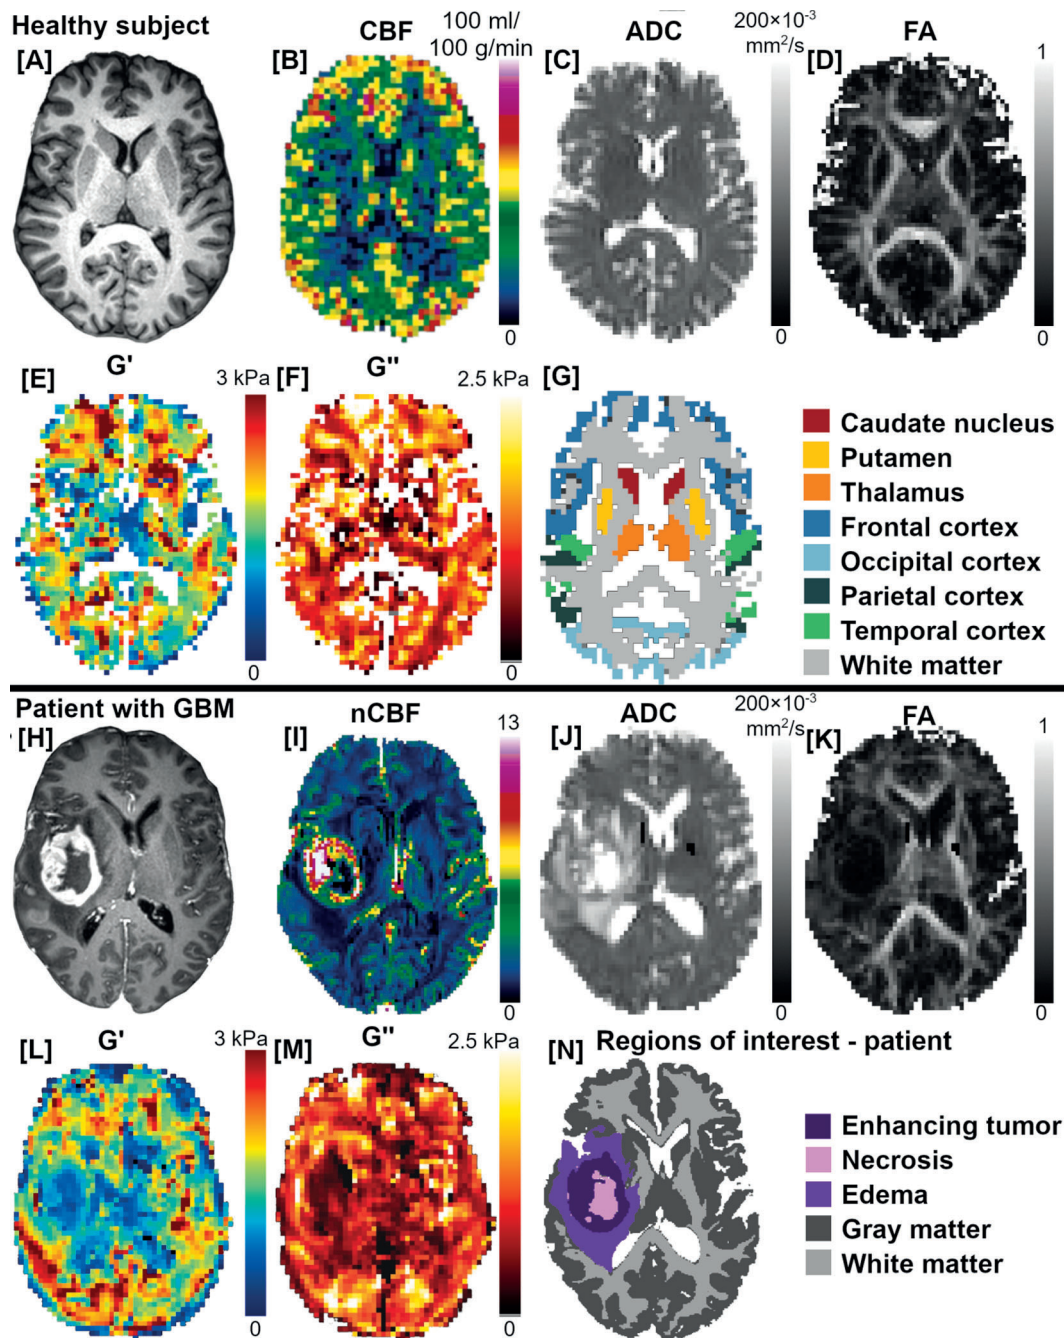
Image example of a healthy subject and patient. A) T1-weighted image, B) CBF, C) ADC, D) FA E) G' , and F) G'' , maps for a healthy subject. G) ROIs used for the healthy subjects, except from hippocampus (not visible in this slice). H) Contrast-enhanced T1-weighted image, I) normalized CBF, J) ADC, K) FA, L) G' , M) G'' maps for a patient with glioblastoma. N) Patient ROIs.
